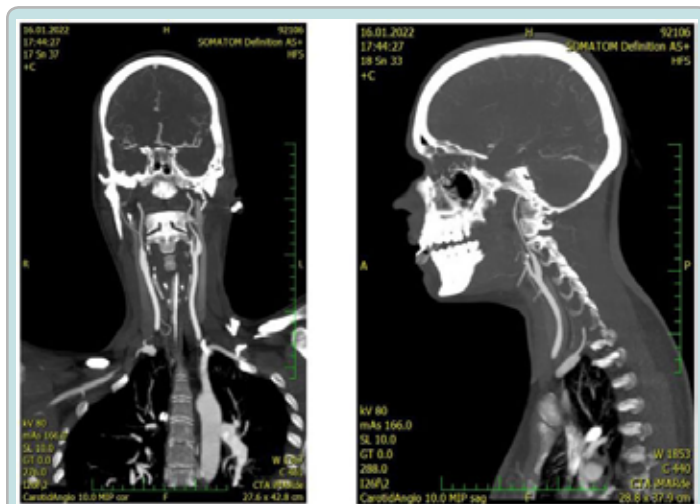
CT scans with vasospasms of cervical segments of internal carotid arteries.
